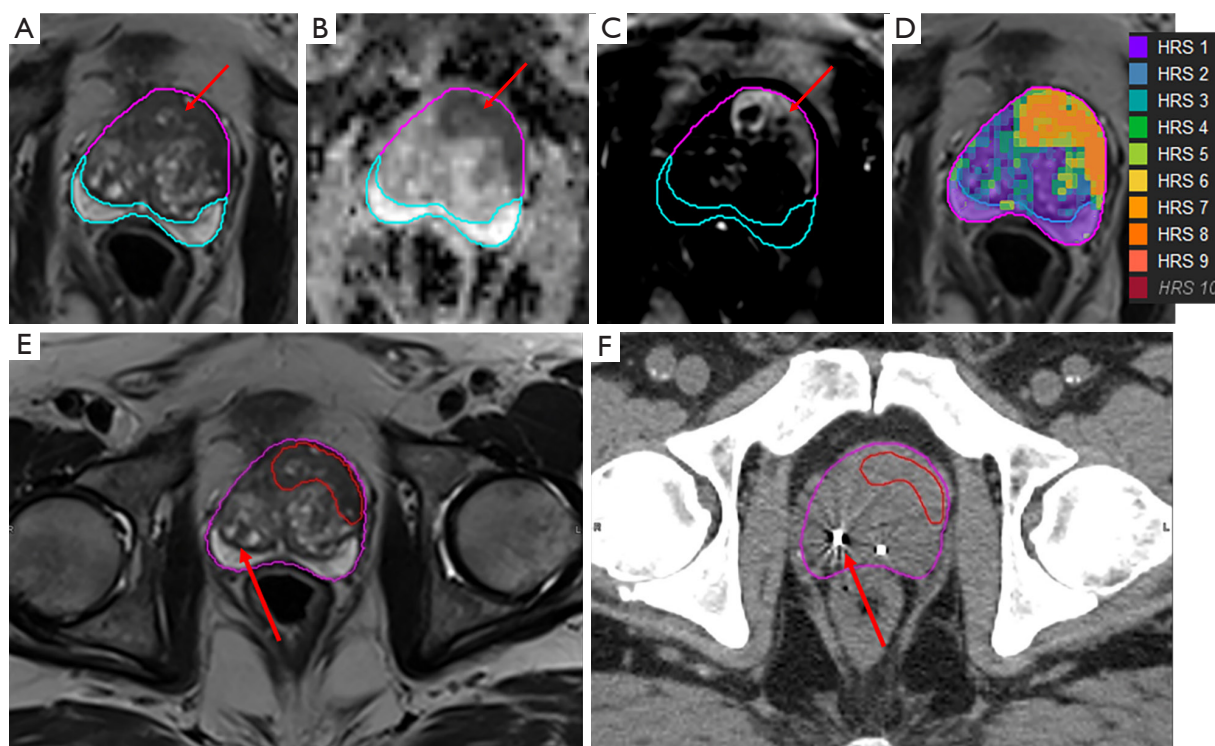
Implementation of Habitat Risk Score (HRS) in radiotherapy planning of a BLaStM patient. (A) An axial slice of the prostate on T2-weighted (T2w) MRI. The red arrow indicates an anterior tumor, characterized with hypo-intensity in the T2w; (B) corresponding slice of apparent diffusion coefficient (ADC) map with area of restricted diffusion (red arrow); (C) early enhancing image from the dynamic contrast enhanced (DCE)-MRI showing increased perfusion in the tumor area (red arrow); (D) Habitat Risk Score (HRS), represented as a heat-map, overlaid on the T2w. HRS is calculated in MIM, using Java plug-in. The approach scores every pixel with a 10-point scale (insert) in increasing risk for cancer. The volume of HRS10 is empty; (E) the 3D volume of the tumor, as depicted by HRS6 is used for gross tumor volume (GTV), the red arrow pointing to a fiducial marker; (F) the planning CT is aligned to the T2w, using fiducial matching (red arrow). The final result is displayed where the smoothed HRS6 contour has been migrated to the planning CT.
